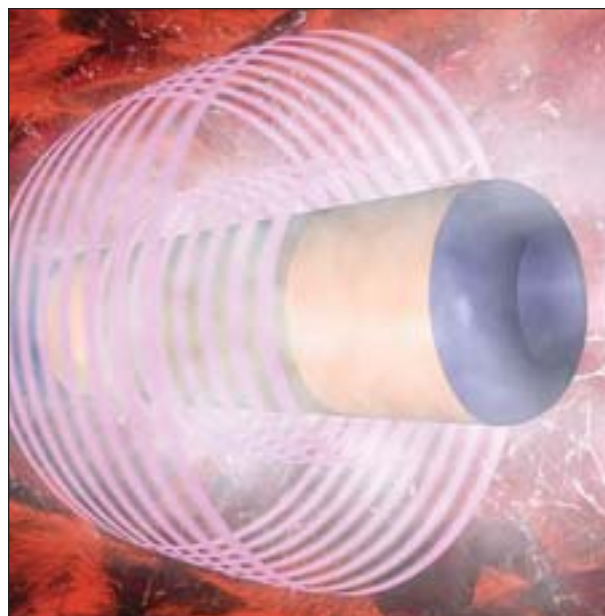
A representation of ultrasound being emitted from the MicroLysis Infusion Catheter tip with increased fluid dispersion.
